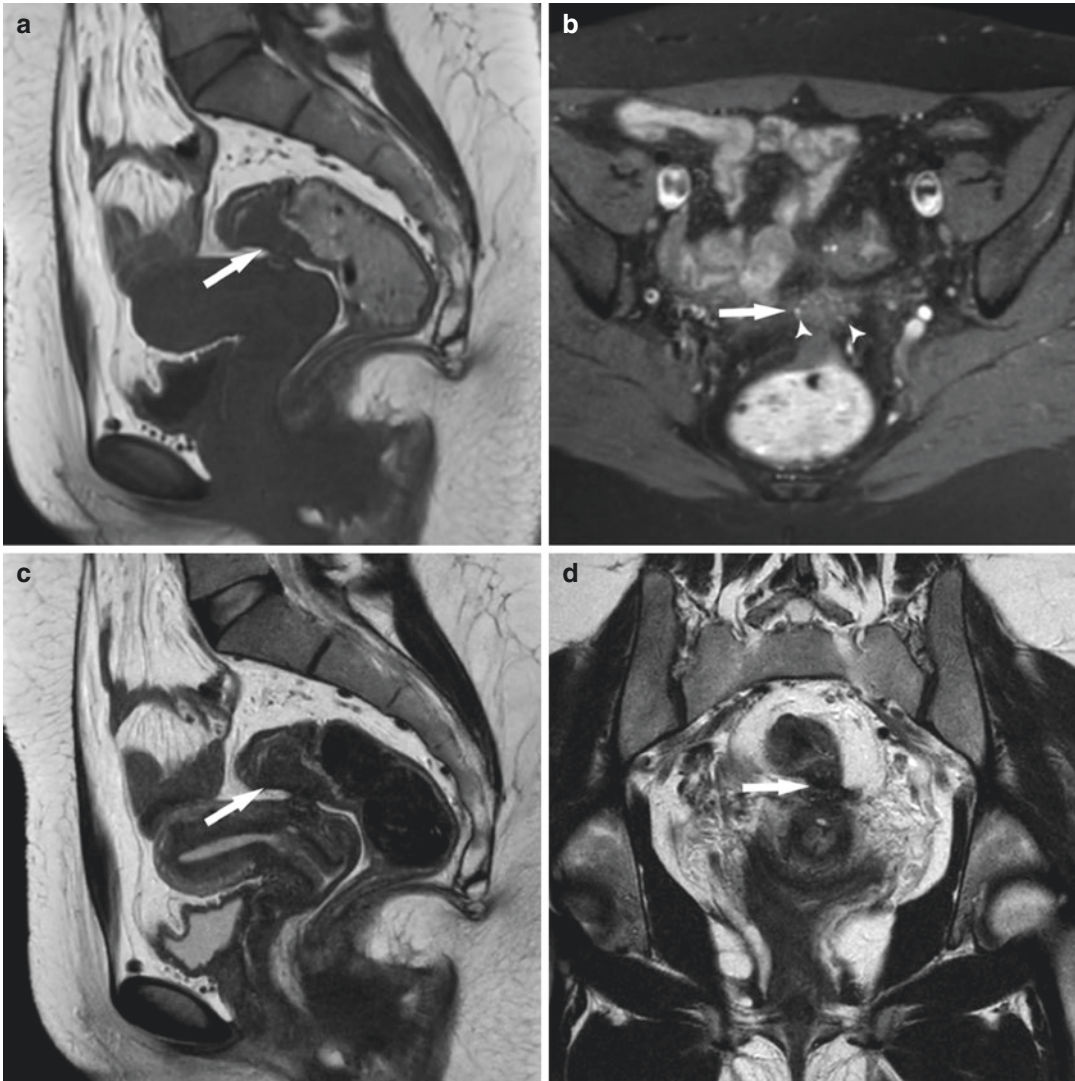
Rectosigmoid endometriosis in a 34-year-old woman with pain during defecation and haematochezia synchronized with menses. Sagittal T1-weighted (a), axial T1-weighted with fat suppression (b), sagittal (c), and coronal (d) T2-weighted MR images show hypointense nodular thickening of the rectosigmoid wall that adheres to the posterior uterine surface. The “mushroom
